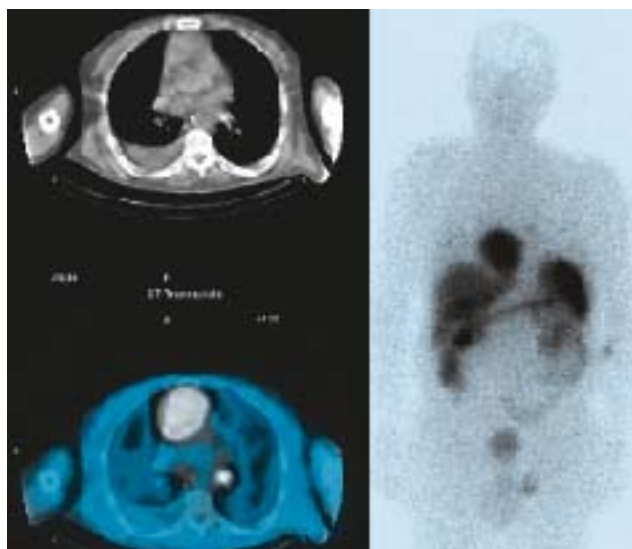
Images after ^{111}In -octreoscan SPET/CT showing high uptake at the right ventricular mass and one hilar lymph node.
